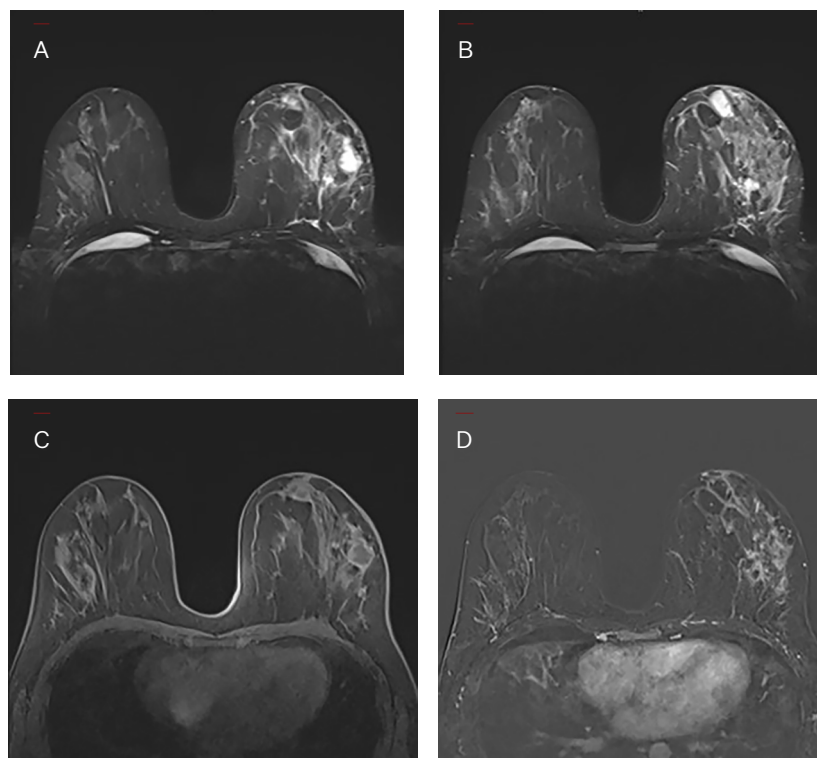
MRI in a 26-year-old female patient who complained of pain and swelling in the left breast and whose pathology result was reported as IGM. (A) and (B) On axial T2-weighted fat-saturated images, cystic lesions are observed in the retroareolar area and outer middle quadrant of the left breast. (C) In the gadolinium-based contrast material-enhanced axial T1-weighted fat-saturated image, there are lesions suggestive of a wall-enhanced abscess in the retroareolar plane and outer middle quadrant of the left breast. (D) In the gadolinium-based contrast material-enhanced axial T1-weighted fat-saturated subtraction image, irregular parenchymal contrast enhancements are observed in the outer quadrants of the left breast.
